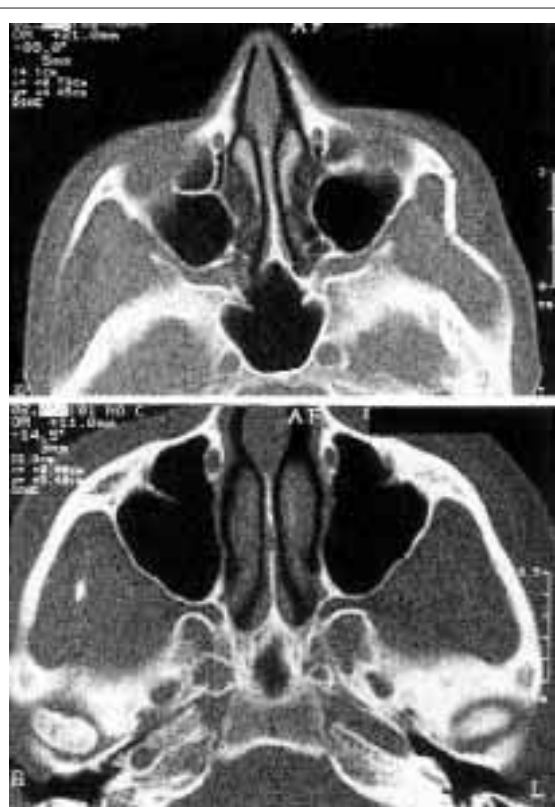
Axial CT showing an isolated fracture of left zygomatic arch (a). CT after closed reduction with blunt elevator by buccal incision (b).
